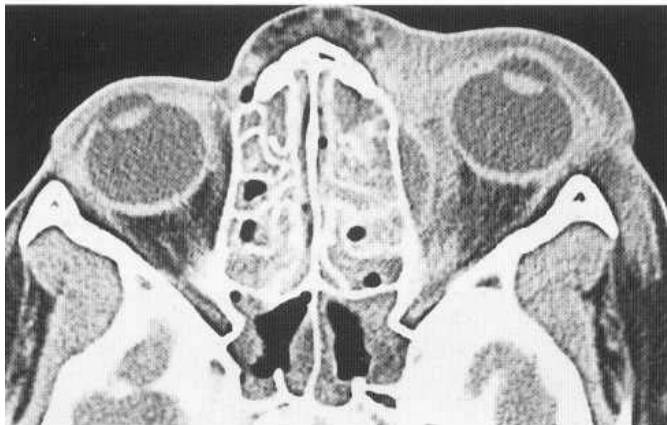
Extraconal orbital abscess from sinusitis. Enhanced axial CT image demonstrates opacification of ethmoid sinuses and mucosal thickening within the sphenoid sinus. There is preseptal cellulitis on the left, with thickening of the eyelid. Low-attenuation subperiosteal abscess in the medial extraconal compartment causes proptosis.
